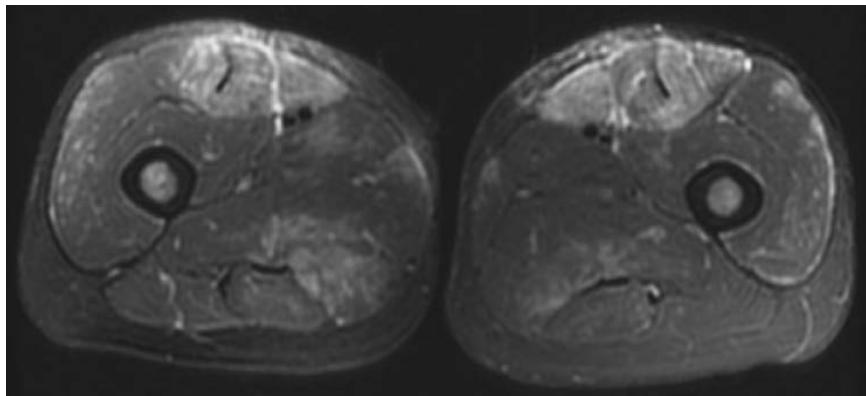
Skeletal muscle MRI with short T1 inversion recovery (STIR) imaging in polymyositis. MRI of the thigh demonstrates bright signal indicative of edema/inflammation, particularly in the rectus femoris muscle. This contrasts with MRI in IBM in which there is more selective involvement of the vastus lateralis and medialis with relative sparing of the rectus femoris (see Fig. 365-7F and G).
